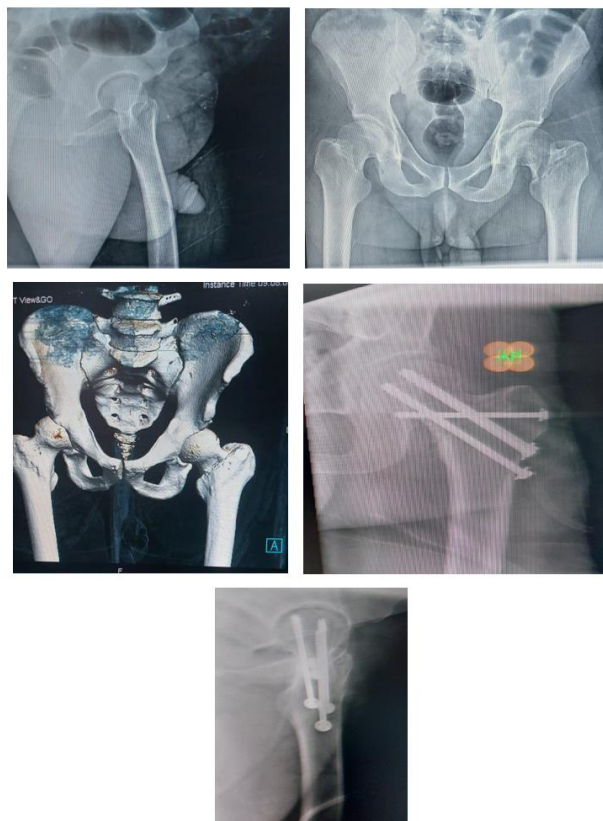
Plain x-ray anteroposterior view showing fixation of the fracture neck of the femur by a cannulated screw with a transtrochanteric screw.
